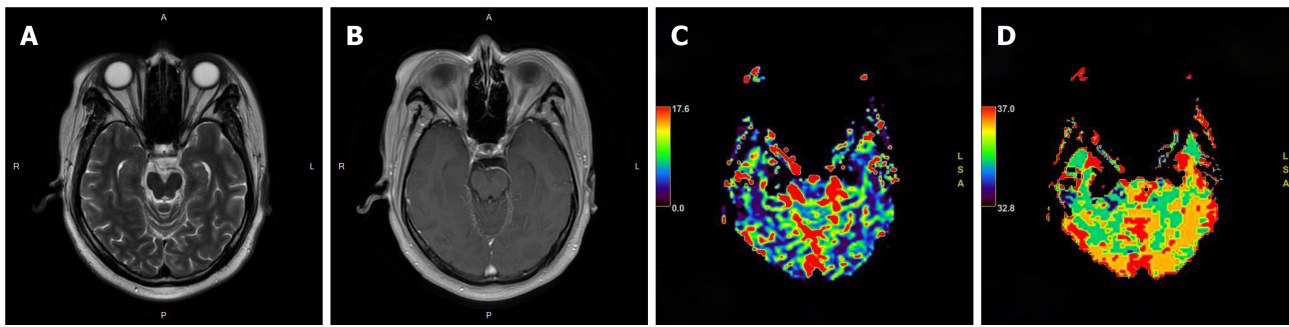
Follow-up magnetic resonance imaging. A: T2-weighted image showing no mass effect; B: Contrast-enhanced magnetic resonance imaging showing no abnormal enhancement; C and D: Perfusion-weighted imaging showing no abnormal perfusion.
